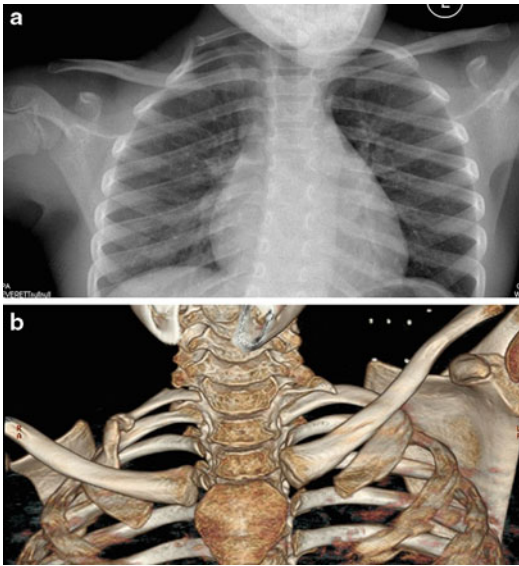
(a) Chest radiograph demonstrates cervical rib on the right side with intervening synchondrosis. (b) CT scan better delineates the cervical rib and synchondrosis (Courtesy of Shriners Hospital for Children, Philadelphia)
